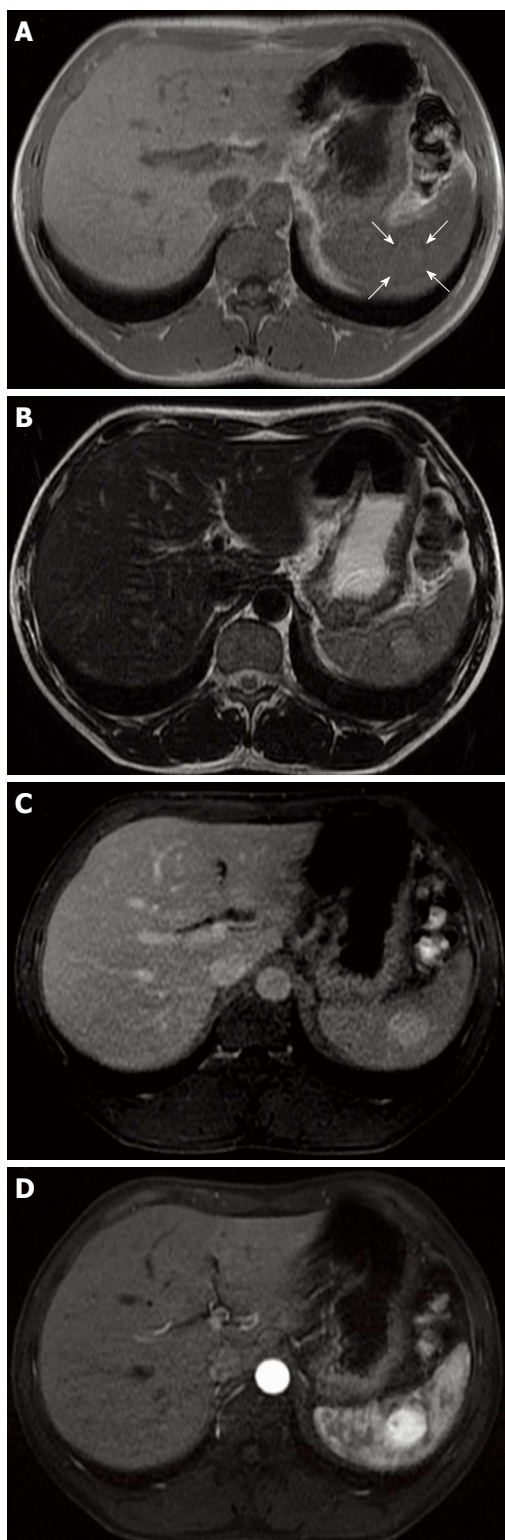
Magnetic resonance imaging (MRI) of the splenic lesion. A: T1-weighted MRI shows the isointense mass (arrows); B: The mass is mildly hyperintense in the T2-weighted MRI; C: The early phase of dynamic MRI shows diffuse heterogeneous enhancement of the mass; D: The mass becomes more enhanced during the delayed phase.
